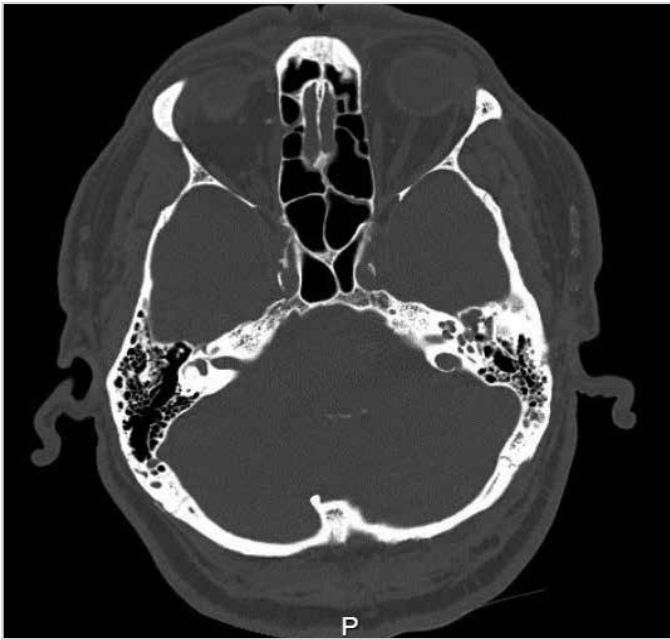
Computed tomography view of the patient with left malignant otitis externa
